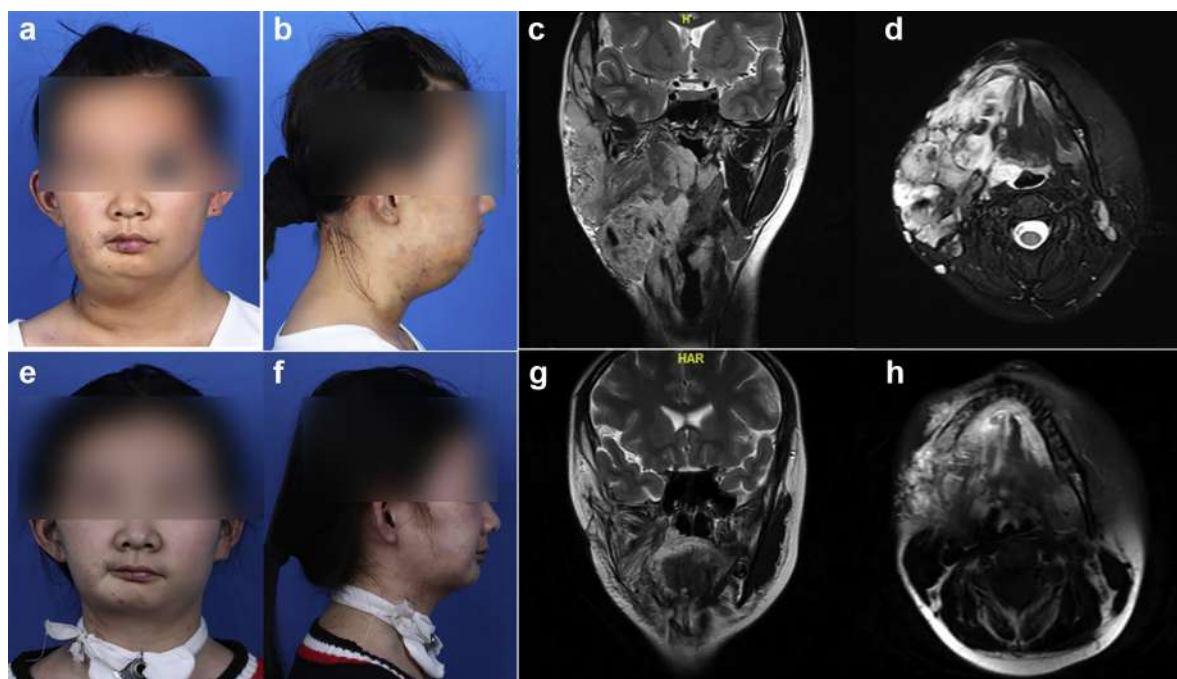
A 16-year-old girl with extensive venous malformation (VM) of the face and neck treated by bleomycin-polidocanol foam (BPF) sclerotherapy. a and b, Clinical appearance before treatment showing extensive lesion and severe deformity. c and d, Pretreatment T2-weighted magnetic resonance imaging (MRI) showing an extensive hyperintense mass of the right facial and neck region. e and f, After tracheotomy followed by six sessions of BPF sclerotherapy, significant improvement of VM lesions was obtained. g and h, Post-treatment T2-weighted MRI 12 months after treatment showing almost complete resolution of VM lesions.
